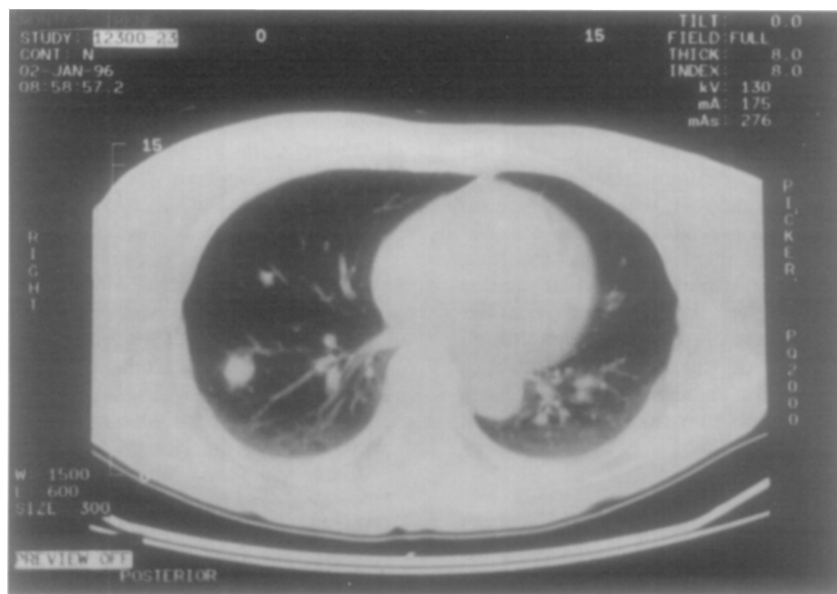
Computed tomogram of the chest with intravenous contrast material showing eccentric soft tissue growth around the right lower lobe lesion.
